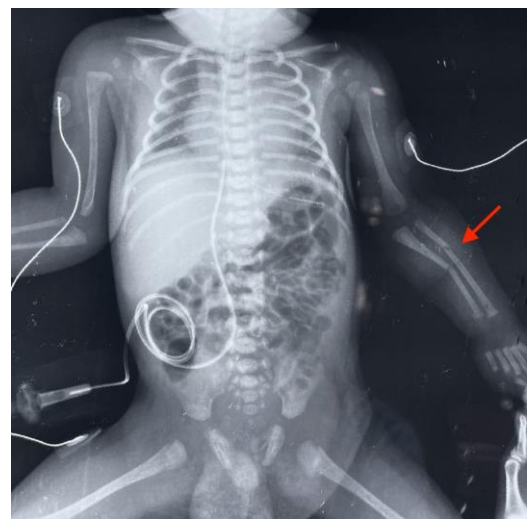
X-ray of the chest, abdomen and upper limbs showing generalized osteopenia with left sided radio-ulnar fracture.
